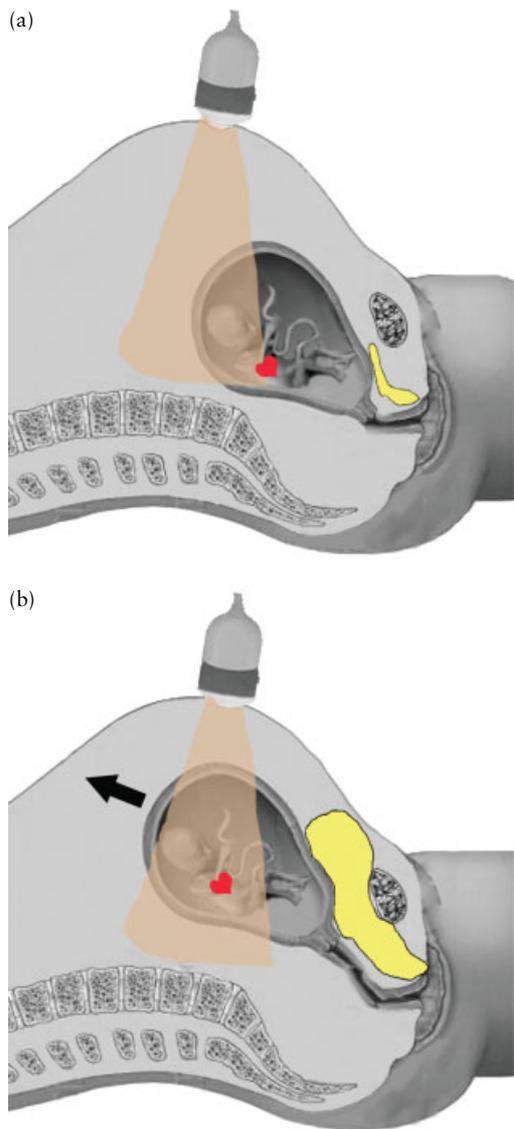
Field of view on ultrasound using a transabdominal periumbilical approach at 20 weeks of gestation. (a) With an empty maternal bladder (yellow) and the fetus in breech presentation, the heart (red) is just outside the field of view of the convex probe and can hardly be evaluated; (b) if the scan is performed with a full maternal bladder (yellow), the uterus is pushed upwards, allowing the operator to explore the fetal heart (red) through the periumbilical area.
